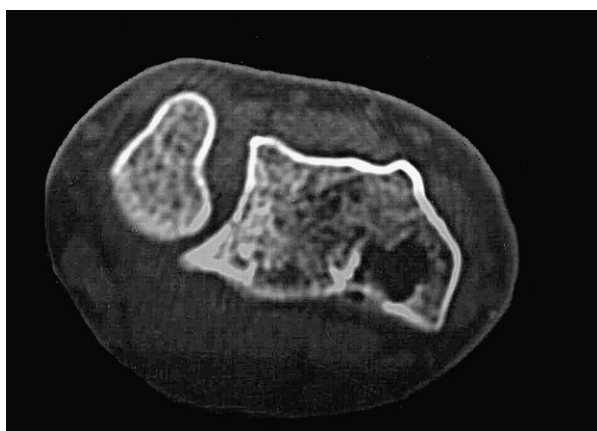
Eighteen months after surgery, an axial CT scan in full supination shows the augmentation of the volar lip of the sigmoid notch and reduction of the DRUJ. Reprinted with permission from Wallwork NA, Bain GI. Sigmoid notch osteoplasty for chronic volar instability of the distal radioulnar joint: a case report. *J Hand Surg.* 2001;26:454–459.
